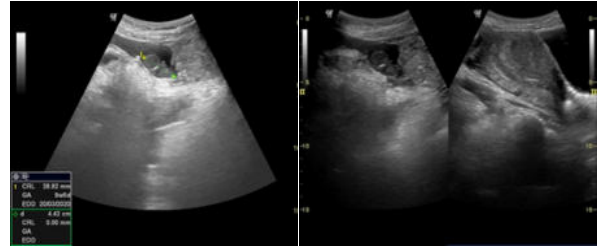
USG showing transabdominal sonography showing empty endometrial cavity with tubal ectopic pregnancy.
